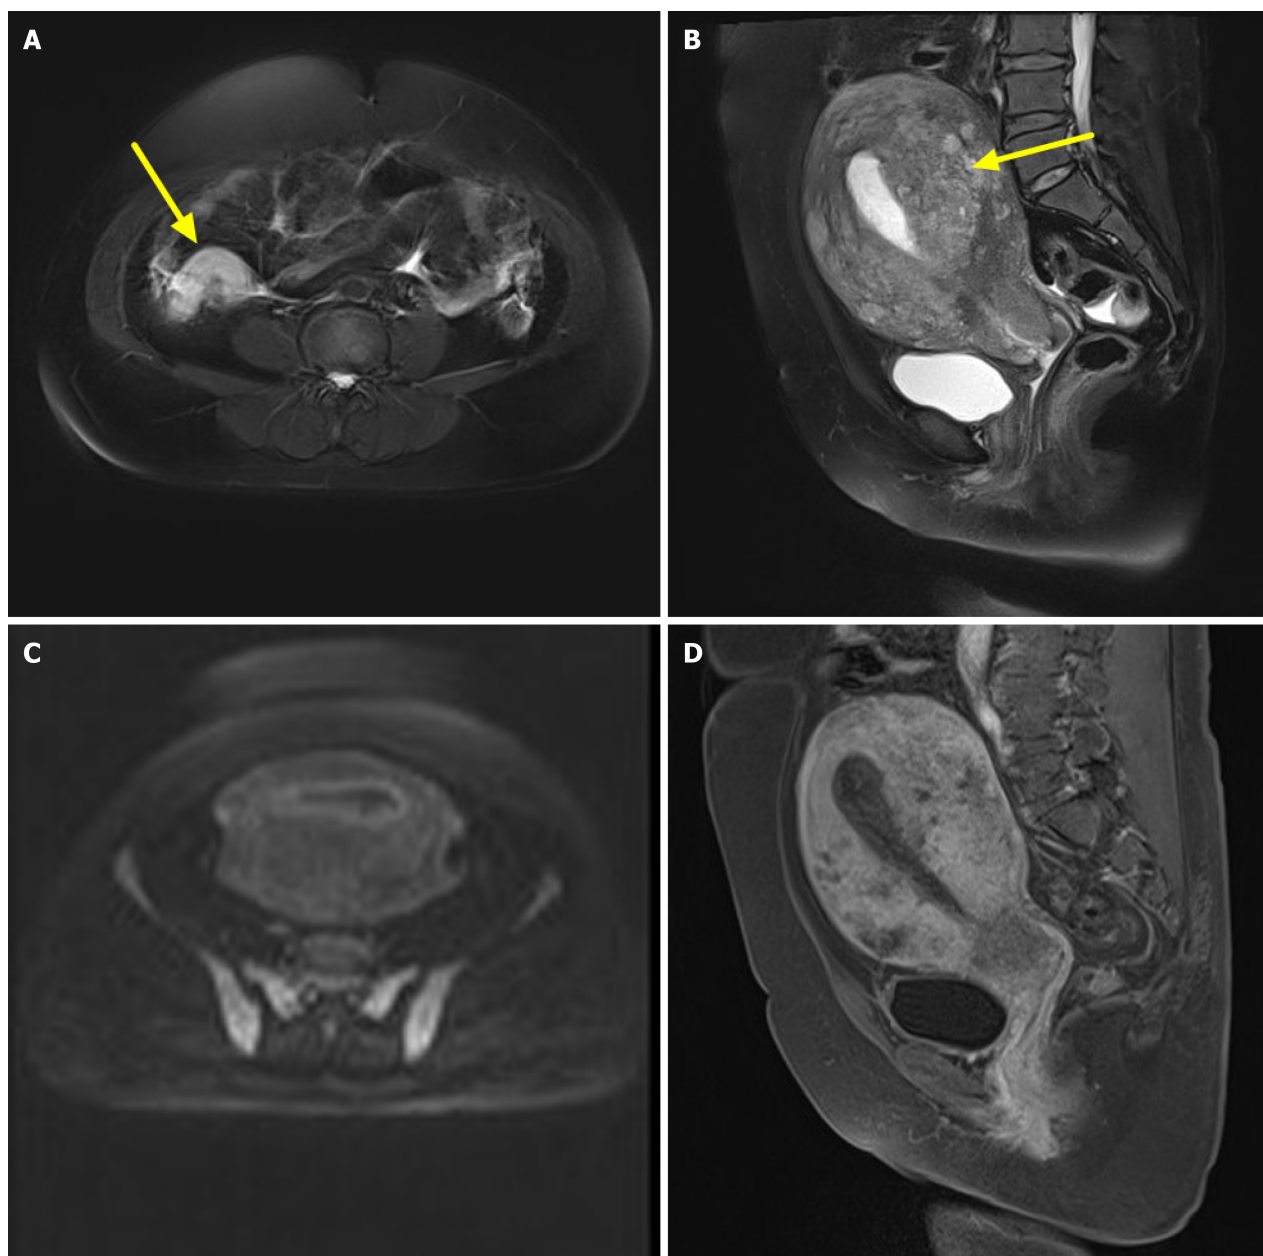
Magnetic resonance imaging features of appendix and uterus. A: T2-weighted imaging (T2WI) transverse view: Coarsening appendix (arrowhead), T2WI high signal, and signals are relatively uniform; B: T2WI sagittal view, obvious thickening mesometrium (arrowhead), and ambiguous display of bonding zone; C: Diffusion-weighted imaging, the enlarged uterus presents slightly high signals; D: T1-weighted imaging enhanced sagittal view, strengthening mesometrium and relatively complete serosa.
